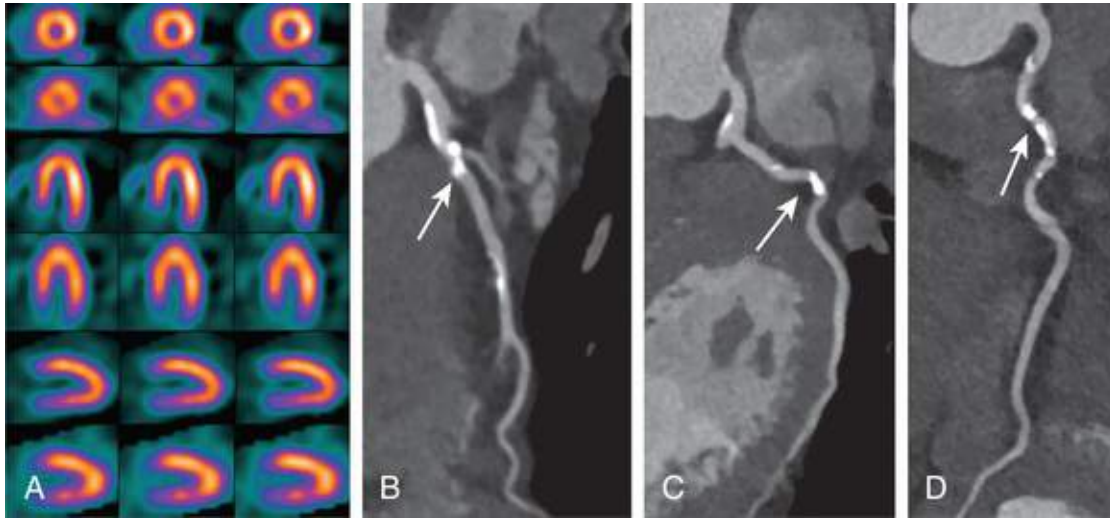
Example of discordance between physiologic and anatomic testing. A, Stress-rest single-photon emission computed tomography (SPECT) study of 66-year-old diabetic man with atypical chest pain shows no myocardial perfusion defect. During the stress test, patient exercised for 8 minutes and 30 seconds on Bruce treadmill protocol. CCTA demonstrates severe calcified plaque that precludes visualization of B, left anterior descending artery; C, left circumflex artery; and D, right coronary artery (arrows).
